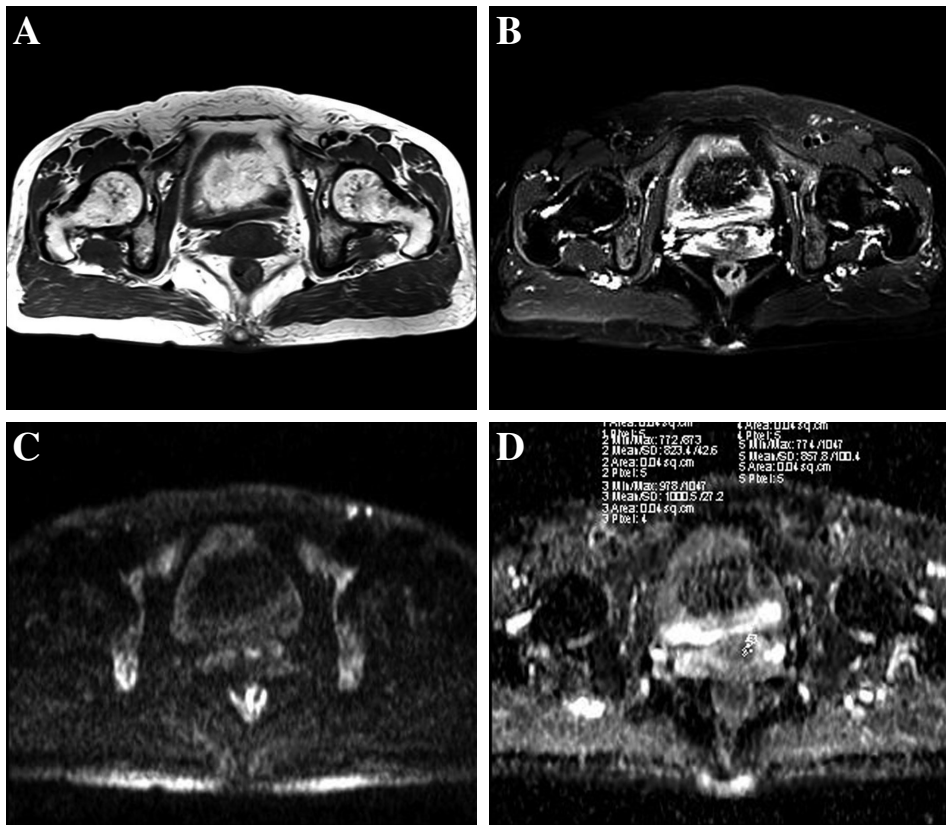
MRI and ADC features in the patients with positive surgical margin after LEEP. A: T1-weighted image shows homogeneous slightly hypointensity in cervix; the focus is unobvious. B: Fat-suppression/T2-weighted image shows the four structures in cervix; the surgical margin presented a hyperintensity similar to the negative surgical margin patients after LEEP. C: DWI image shows the four structures in the cervix; the hydroptic margin has a hyperintensity. D: In the ADC map, the ROIs were measured five times along the surgical margin of cervix, the mean value of ADC was $0.864 \times 10^{-3} \text{ mm}^2/\text{S}$.
